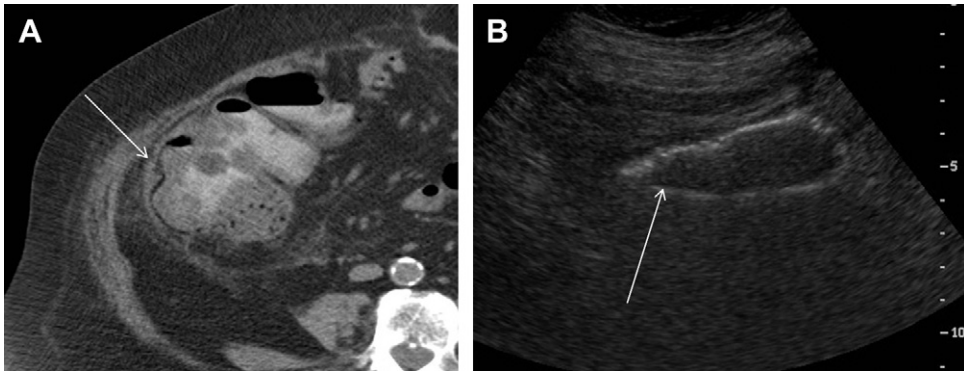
(A) CT scan demonstrated wall thickening of the right colon. Pneumatosis was questioned (*arrow*). Lactate normal. (B) US clearly confirmed the presence of pneumatosis (*arrow*) and also showed no Doppler signal (not shown), favoring ischemia over inflammation.
